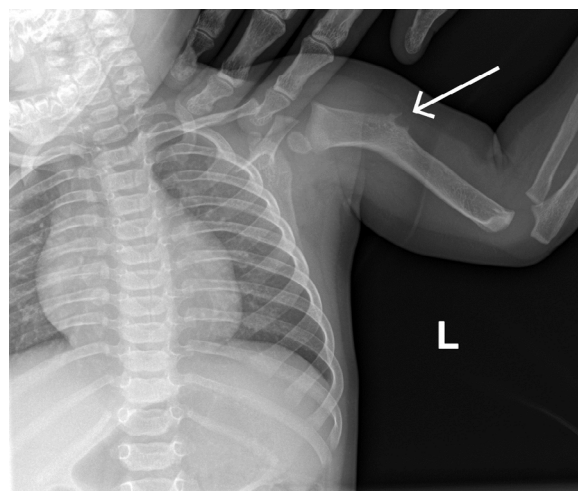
Follow-up of radiography obtained at 8 months of age, showing persistence of the diaphyseal lesion and a spiculated image.
